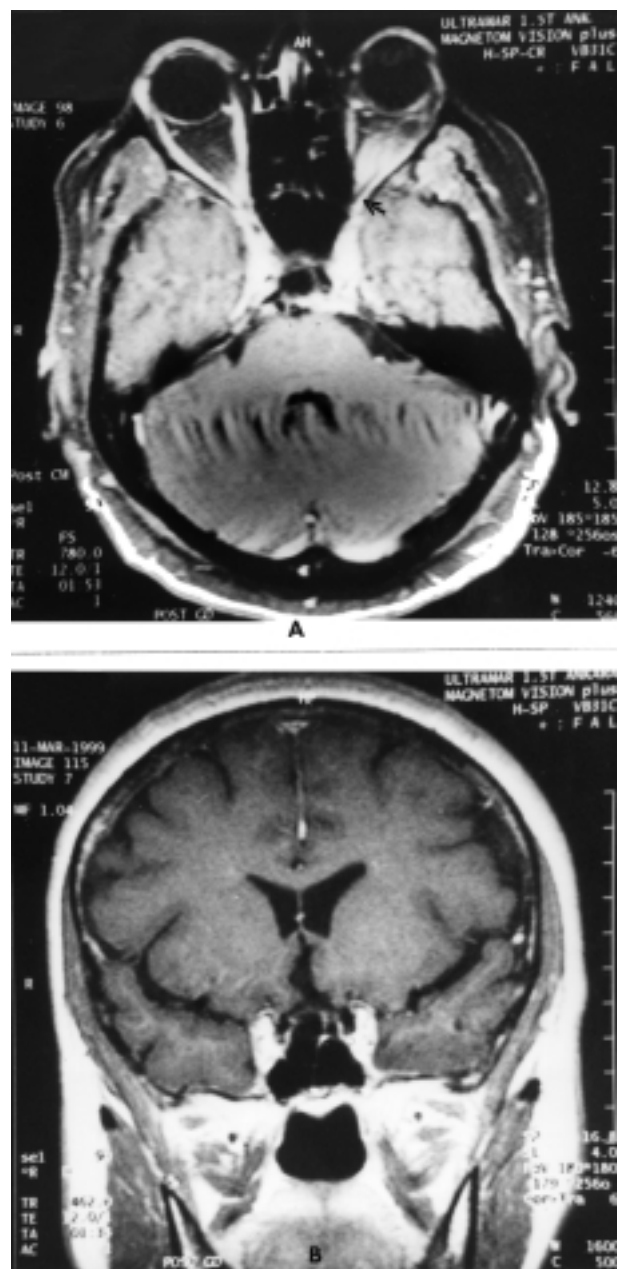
Magnetic resonance imaging. (A) T2-weighted axial image showing dilated left superior ophthalmic vein (arrow). (B) T2-weighted coronal image. No cerebral lesions suggestive of sinus thrombosis are present.
